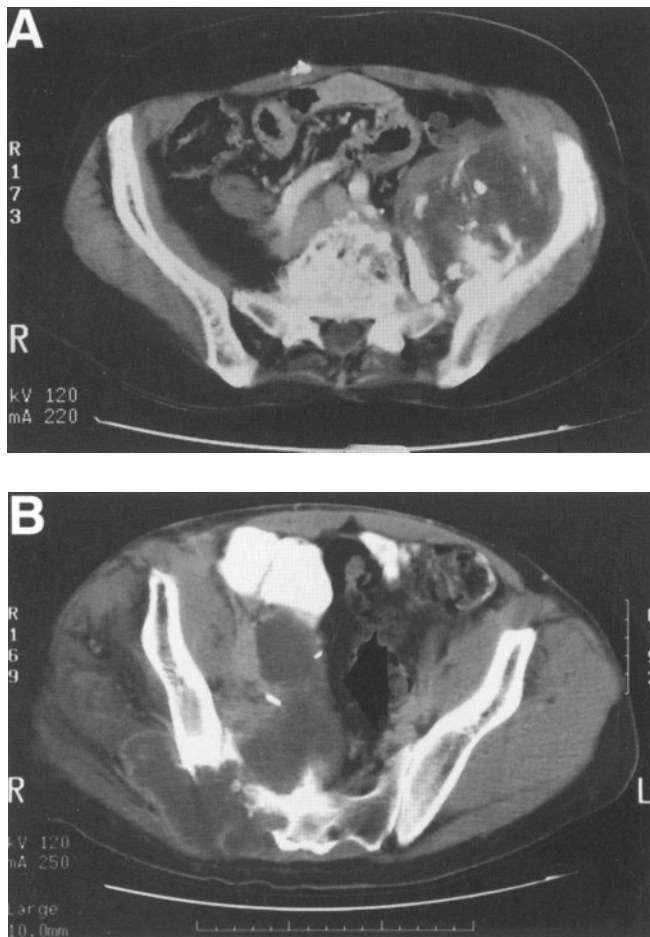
CT scans of two different patients demonstrating the inoperability of large sarcomas around the pelvis that may involve the sacrum. (A) CT scan of a radiation-induced osteosarcoma of the left ilium that crosses the sacroiliac joint and involves S1 and L5. Note the large intrapelvic component with S-I joint involvement and destruction. (B) CT scan of an extremely large chondrosarcoma arising from the right posterior wing of the ilium and sacroiliac joint with marked involvement of the sacrum with a huge intrapelvic extension crossing the midline (arrow). Note the hemoclips that denoted the area of an open biopsy and exploration. There is marked tumor necrosis following postoperative radiation therapy. This patient was inoperable due to the local extension of the tumor intrapelvically and intraspinally.
